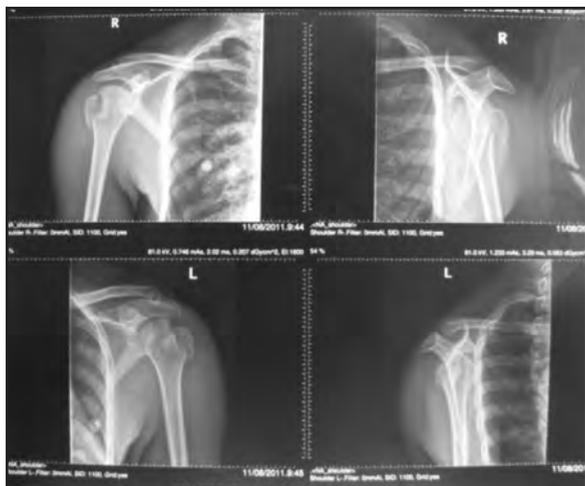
Post-closed reduction AP and lateral views of right and left shoulder X-rays
